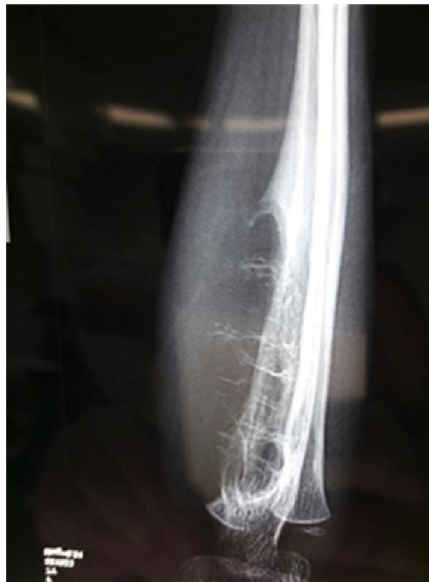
X-ray image showing bone tumor in ulna that destructs the one cortex and fine bony trabeculation the extend to soft tissue.
